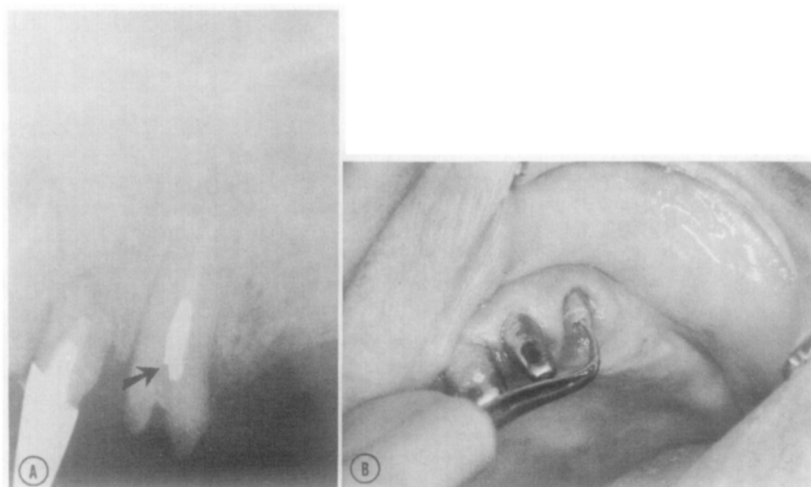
A, Cast post fragmented within canal and notched (*arrow*) for better contact with ultrasonic probe. B, Probe parallel to post.
